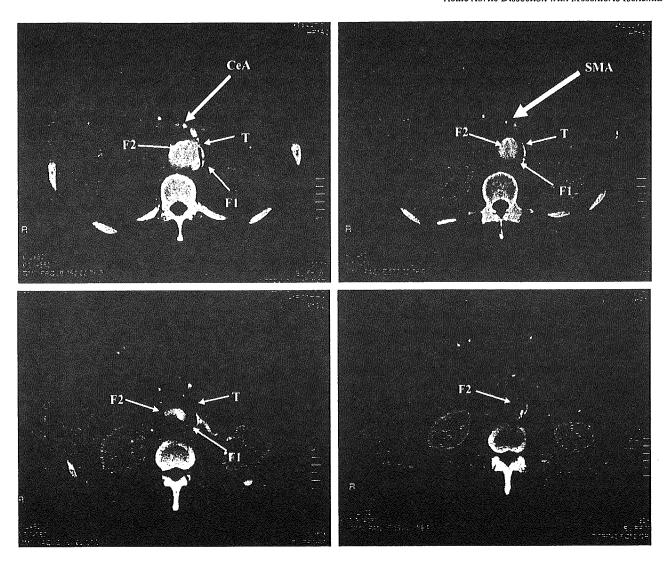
A CT scan obtained 9 days after the onset of symptoms shows that the second false lumen (F2) is further expanded and that thrombosis has developed in it. The true lumen (T) is more severely compressed.
